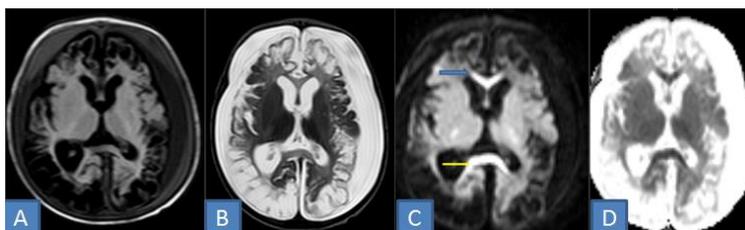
Axial T2 (A) and FLAIR (B) images show cystic encephalomalacic changes in frontal, parietal, occipital and temporal lobes on both sides involving grey and subcortical white matter. DWI images(C) show restriction in Genu (marked in blue), Splenium (marked in yellow) of corpus callosum suggestive of acute hypoxic (ischemic) injury.
